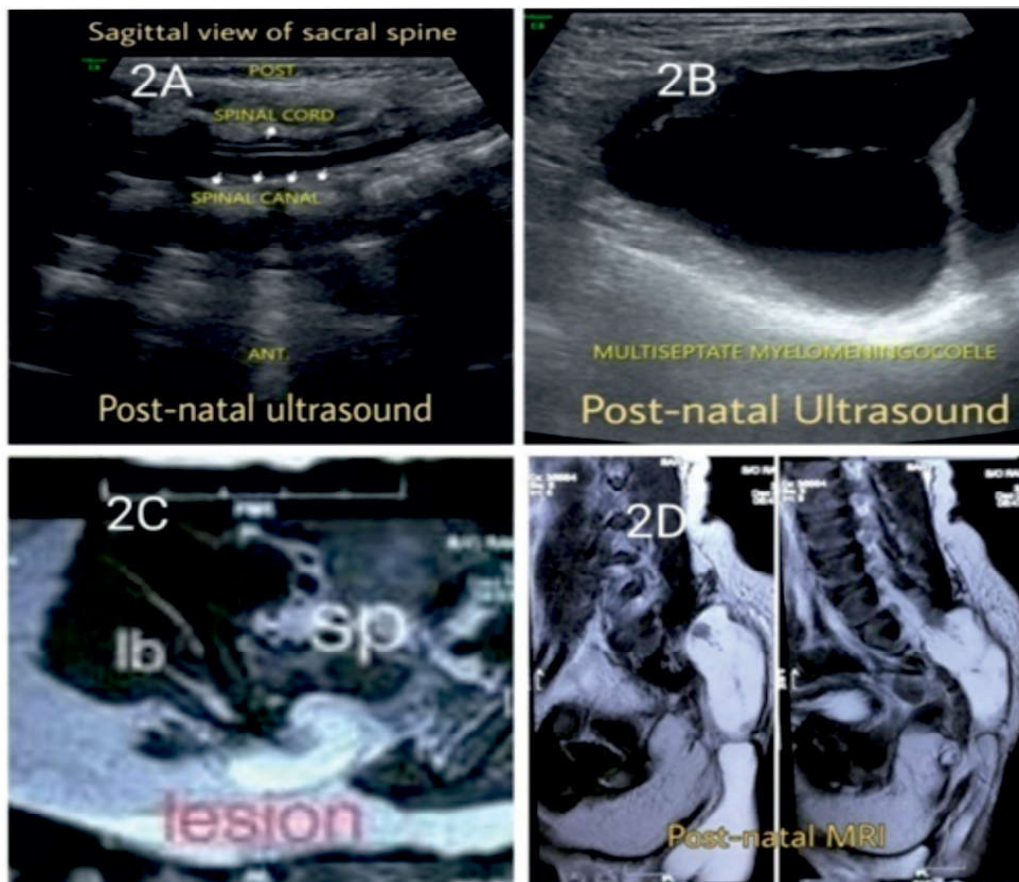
Showing post natal ultrasound and MRI findings.
